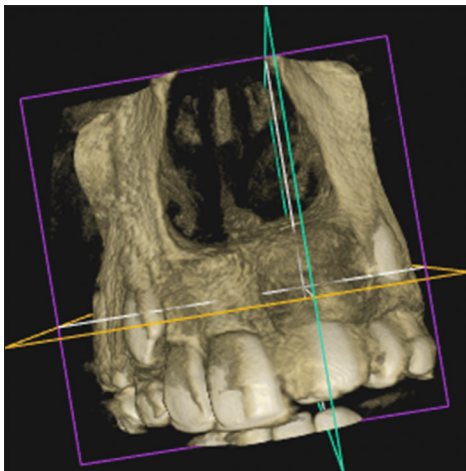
Cone-beam computed tomography showing a unilocular radiolucency involving buccal cortex in the 21 and 22 region
